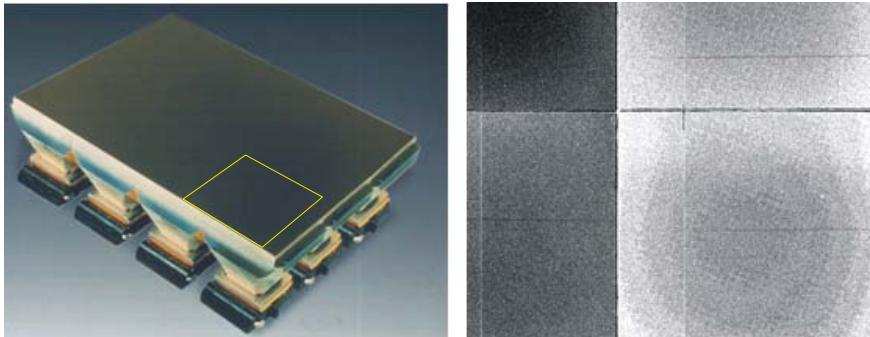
An early digital X-ray detector prototype is shown, which consisted of a phosphor screen coupled to an array of fibre optic tapers and CCD cameras. The image on the right is a measurement of the per pixel variance on a small region indicated by yellow on the detector face. The pattern seen is caused by the junctions of the fibre optics and optical vignetting and other optical aberrations in the fibre optics, which result in strong spatial dependencies of both the signal and noise properties of the detector.
